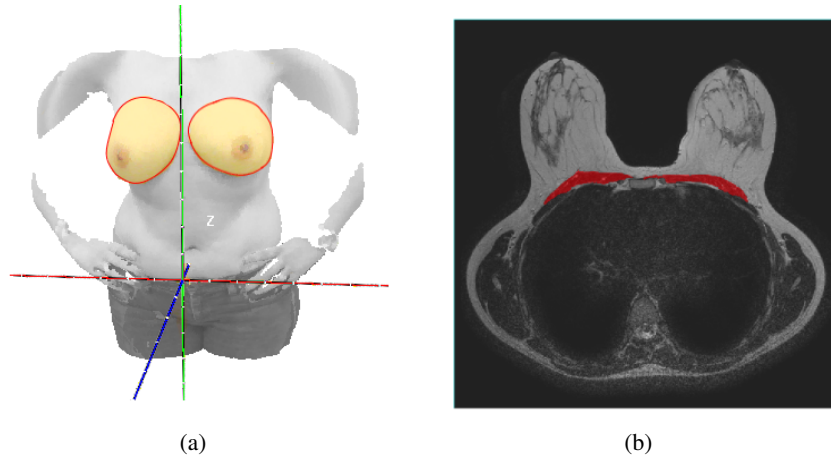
Input data: (a) RGB-D reconstructed data – breast region delimited by the red contour, and (b) MRI slice data – pectoral muscle delimited by the red region
